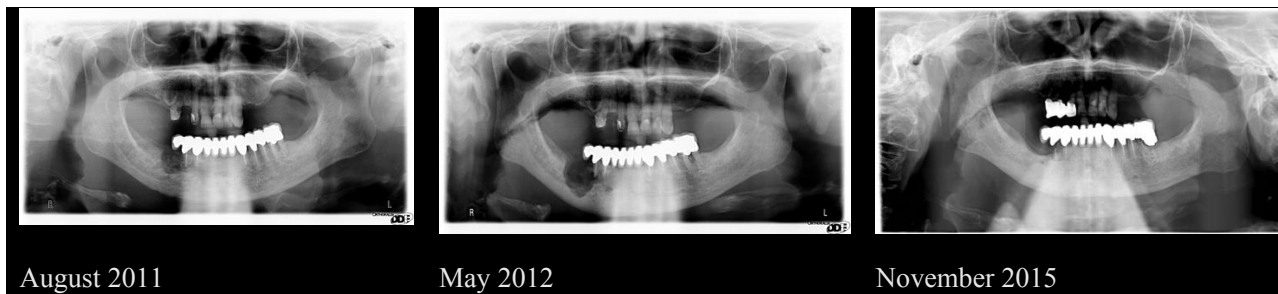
Orthopantomography
